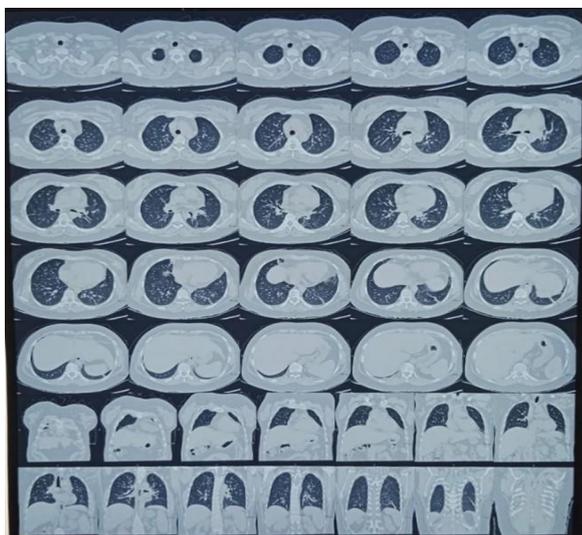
HRCT of lung suggestive of active infective aetiology in form of multiple discrete and randomly distributed nodular infiltrates and bilateral pleural effusion.
